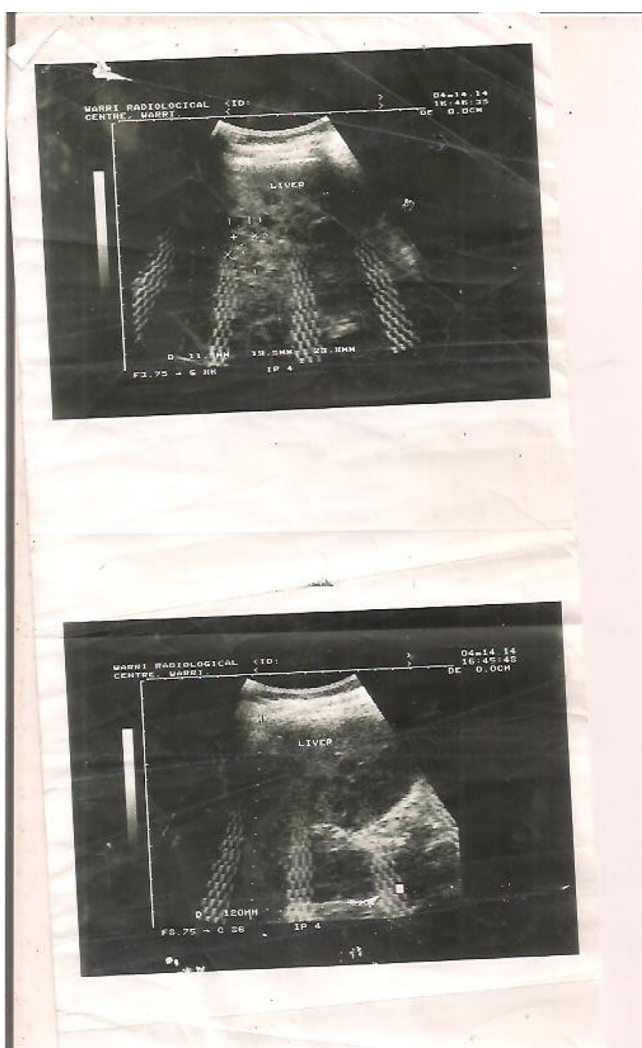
Abdominal ultrasound photo showing a nodular liver.
